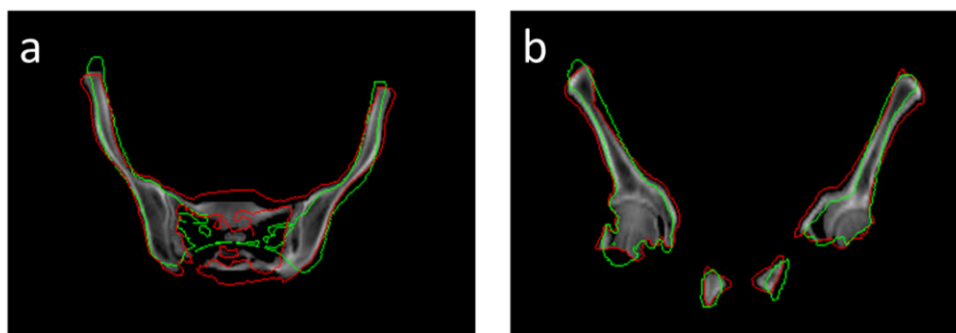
Contours of two deformation samples (red and green) using the first principal mode with the respective coefficients of 5 and -15 of the standard deviation of the population, with the reference CT images (grey) in the axial (left) and coronal plane (right).
